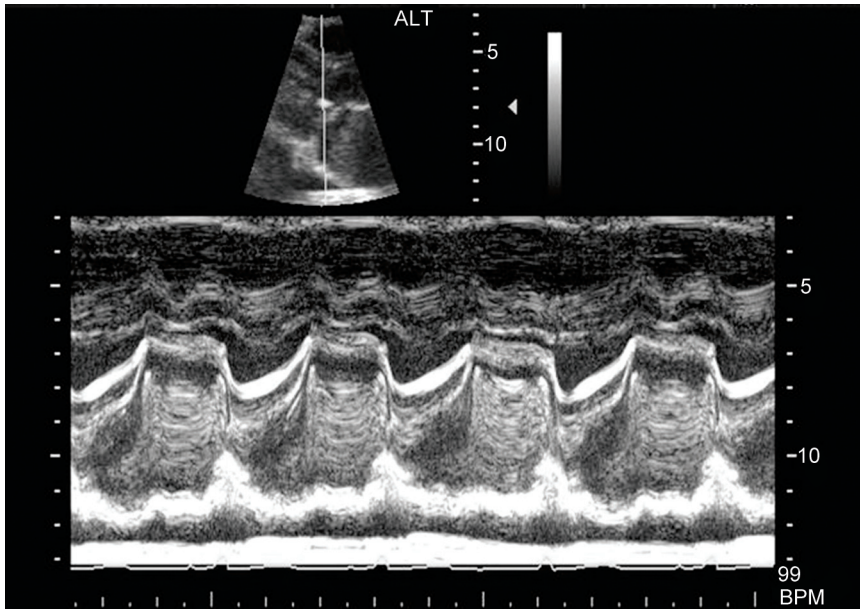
Echocardiogram showing left atrial myxoma. Note the clear lag period after opening of mitral leaflet
